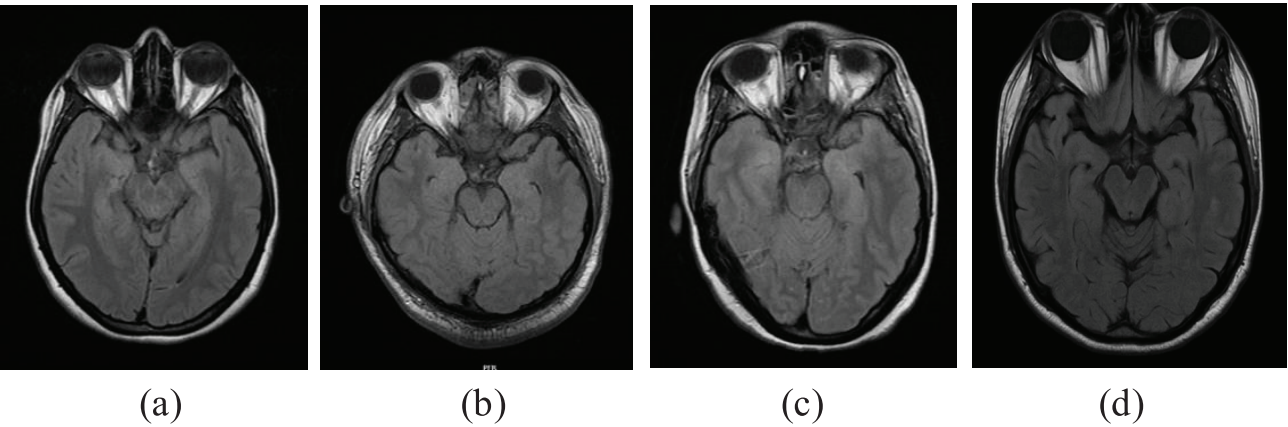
(a-c) Axial FLAIR MRI of the brain in a patient with seronegative AIE. The image shows normal signal intensity in the mesial temporal lobes and basal ganglia at this level, without overt evidence of hyperintensities or oedema. Despite the absence of radiological abnormalities, the clinical presentation and CSF findings were consistent with AIE, highlighting the diagnostic challenge in seronegative cases. (d): Axial FLAIR MRI in a patient with seronegative AIE. Mild cerebral atrophy is noted with prominence of cortical sulci and ventricles, without focal signal abnormalities.
